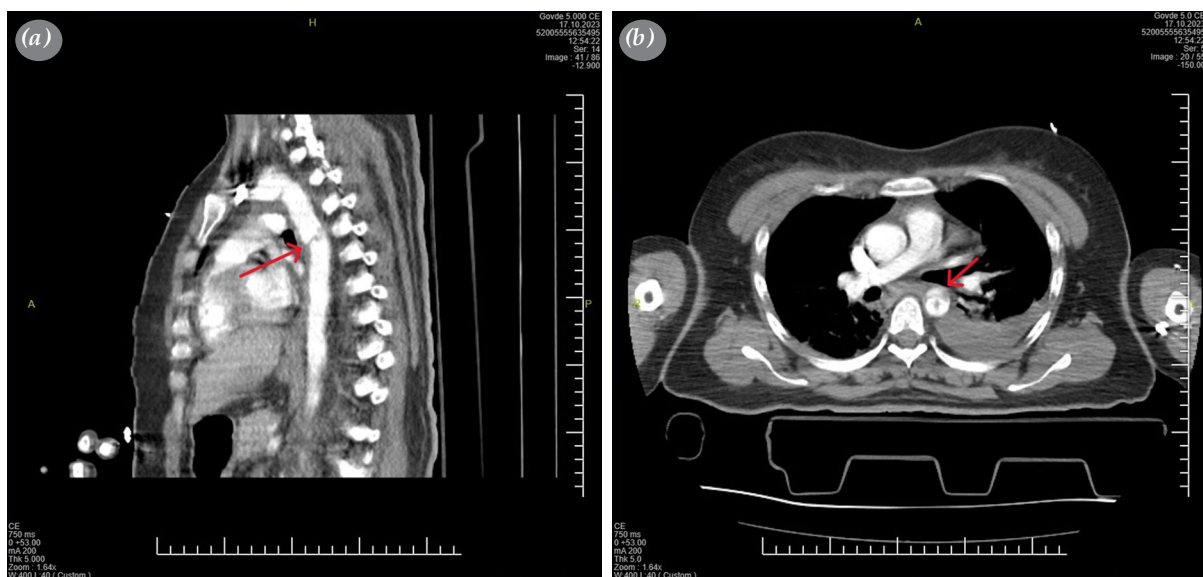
(a) Sagittal CT image of near complete transection. (b) Axial CT image of transection.
